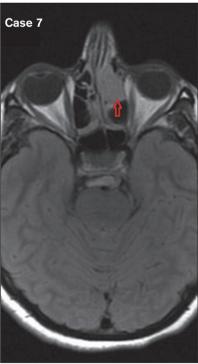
Magnetic resonance images of paranasal sinuses (cases 1 through 7).
